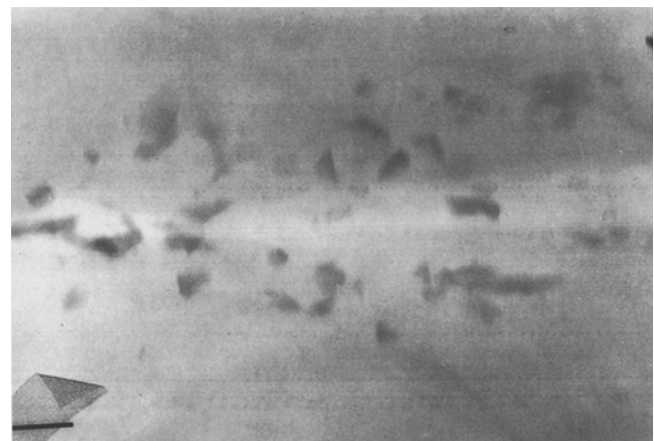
Glass dust in the surroundings of a laceration. Direct X-ray magnification (40 \times)
